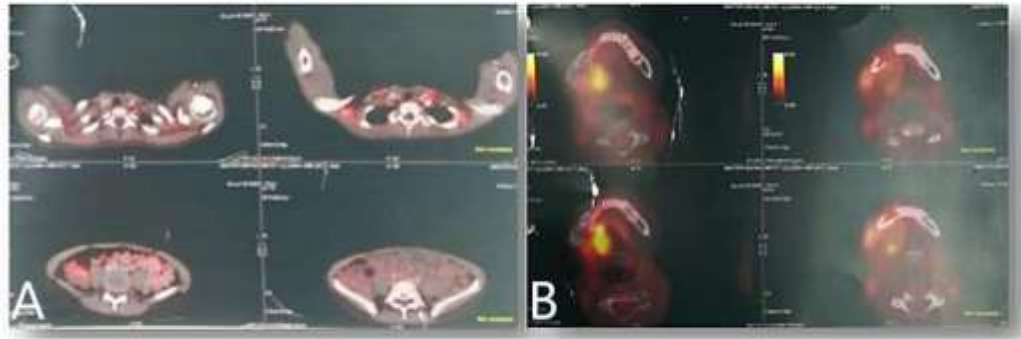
A, B- PET CT post chemotherapy
